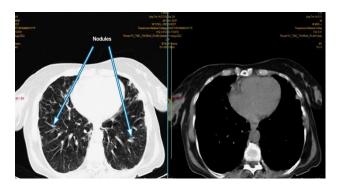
CT chest showed random pulmonary nodules with post covid bronchiectatic changes.
